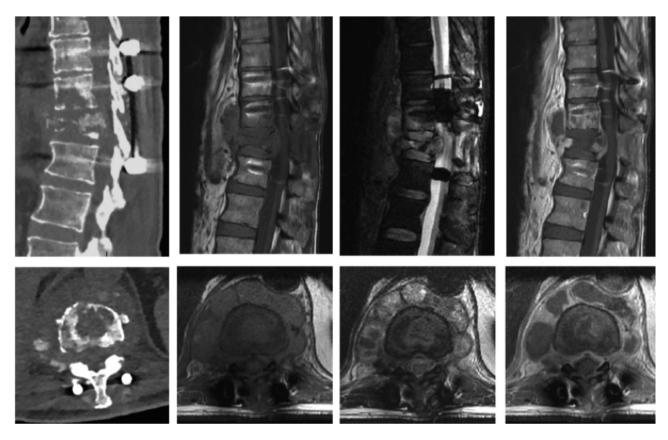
Left pannels: sagittal (top) and transverse (bottom) CT scan views of thoracic vertebrae following arthrodesis of T12 for a pathological fracture. Subsequent images: paired sagittal (top) and transverse (bottom) MRI views of the thoraco-lombar region in T1, T2 with suppression of the fat signals and T1 following injection, respectively. Osteolytic destruction of T12 can be observed, with extention of the infection to the surrounding soft tissues and a large epidural leak; calcifications are best seen on the CT images. Such destruction of a vertebral body, with extention of collections to the surrounding soft tissues, particularly to the anterior paraspinal space, is very suggestive of a tuberculous spondylitis, especially when found in patients of Asian, Oriental or African origin.
